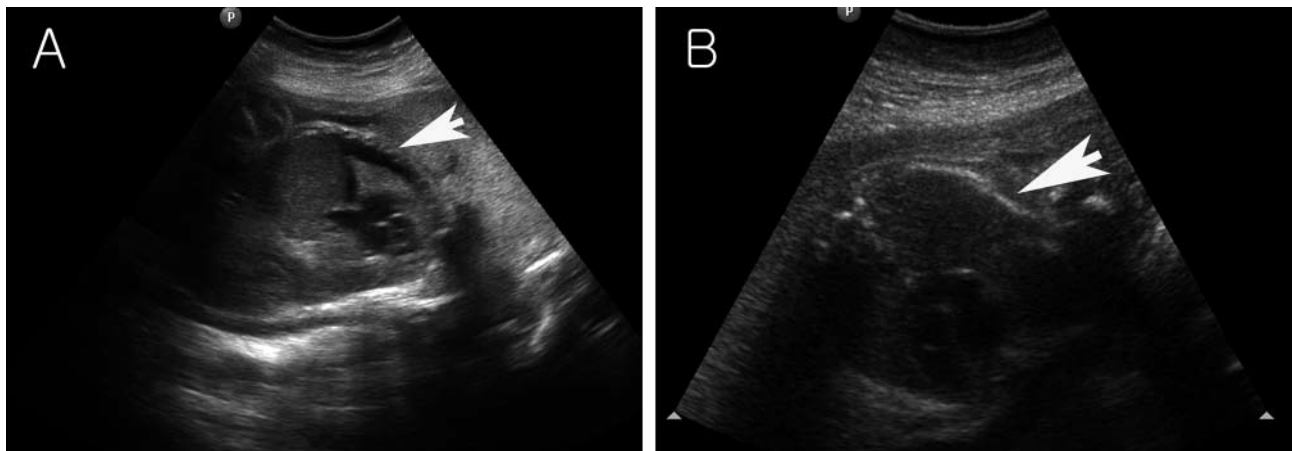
Prenatal ultrasonography confirmed transient fetal pleural effusion. A) Coronal section of the thorax and abdomen of a 27-week fetus, showing anechoic space (arrow) peripherally around the lung in the right thorax, suggesting unilateral pleural effusion. B) At 28+5 weeks' gestation, a transverse section of fetal thorax appeared normal (arrow) after spontaneous resolution of right pleural effusion.
